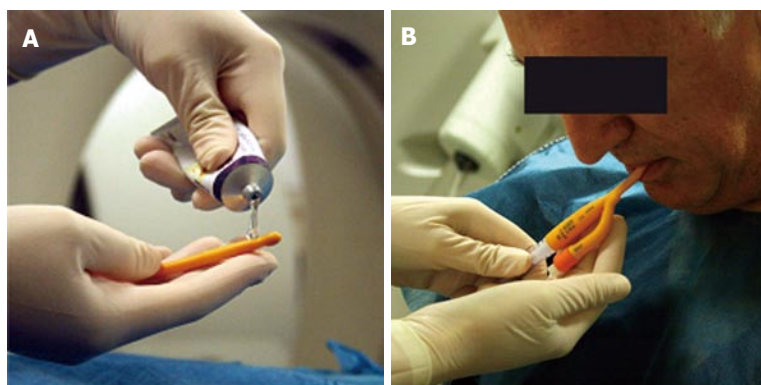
Pneumo-computed tomography technique. A: The tip of the Foley catheter is lubricated with gel anesthesia; B: The Foley catheter is introduced transorally.
